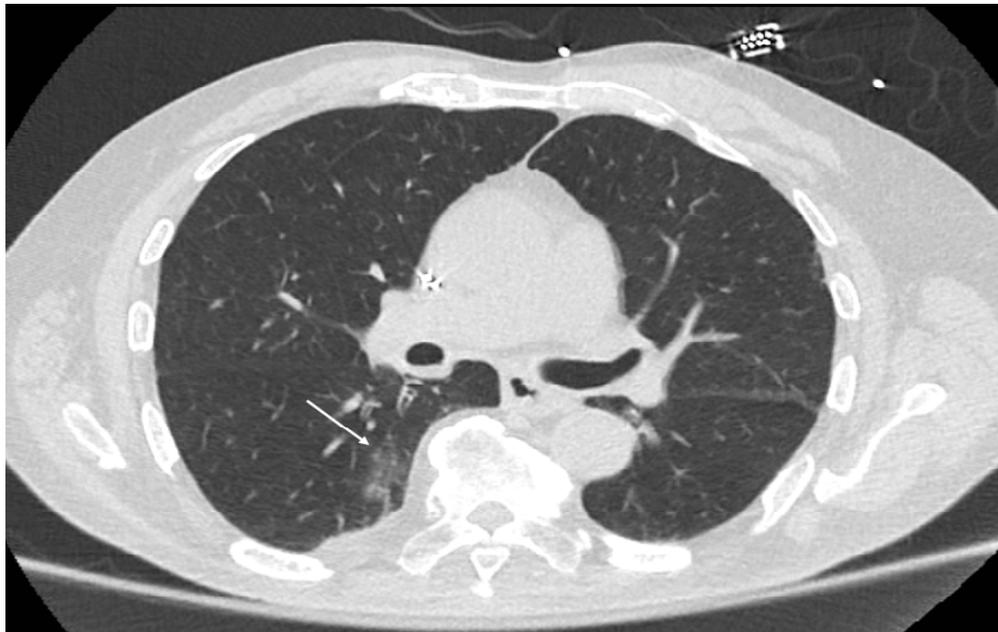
CT Chest demonstrating right lower lobe ground glass opacity (white arrow)
